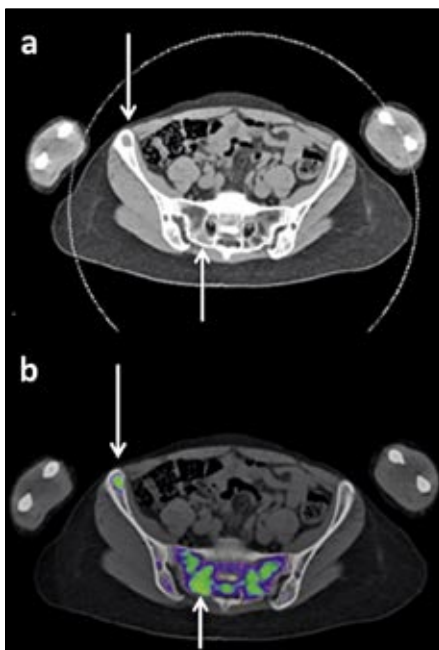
Focal bone marrow infiltration (arrows) in a patient with multiple myeloma. Visualization of bone marrow in Standard-CT (a) is hampered by the dense trabecular structure of the cancellous bone. Dual Energy CT (b) clearly depicts focal infiltration in the sacral bone and the iliac crest.
